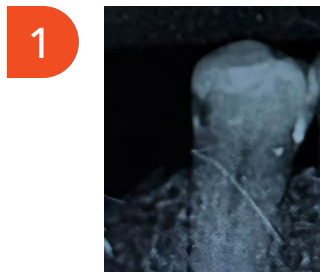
Radiographic examination confirmed the presence of a mesial carious lesion on tooth #45.
